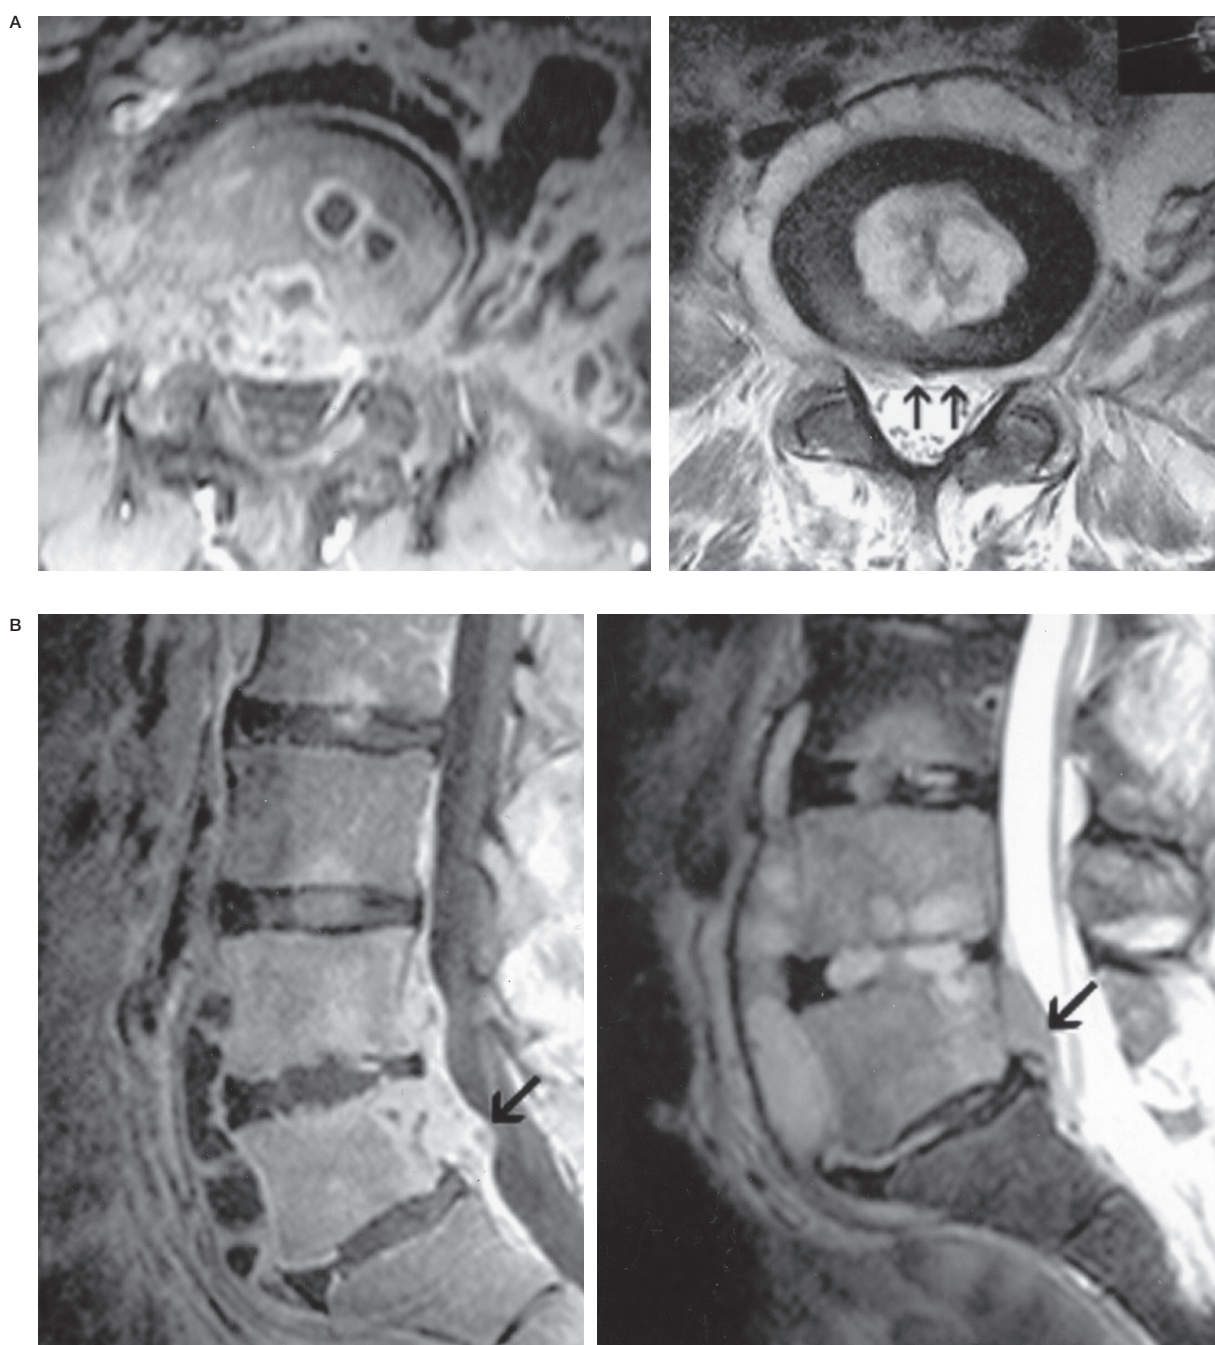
A,B) Intravenous contrast enhanced T1-weighted and T2-weighted MR images reveal spondylitis of the vertebrae of the L2, L-3, L-4, and L-5 with discitis. These images more clearly show multiloculated paravertebral abscess, epidural extension (arrows), and contrast enhancement of the abscess.
